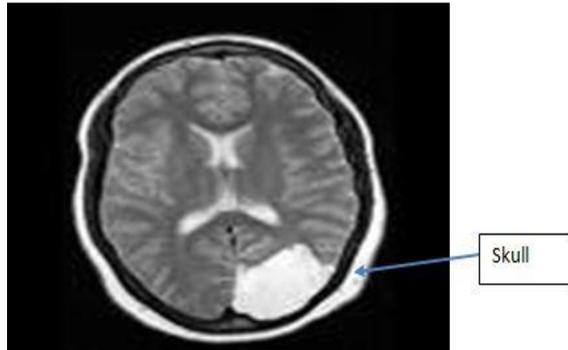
Skull part in MRI
